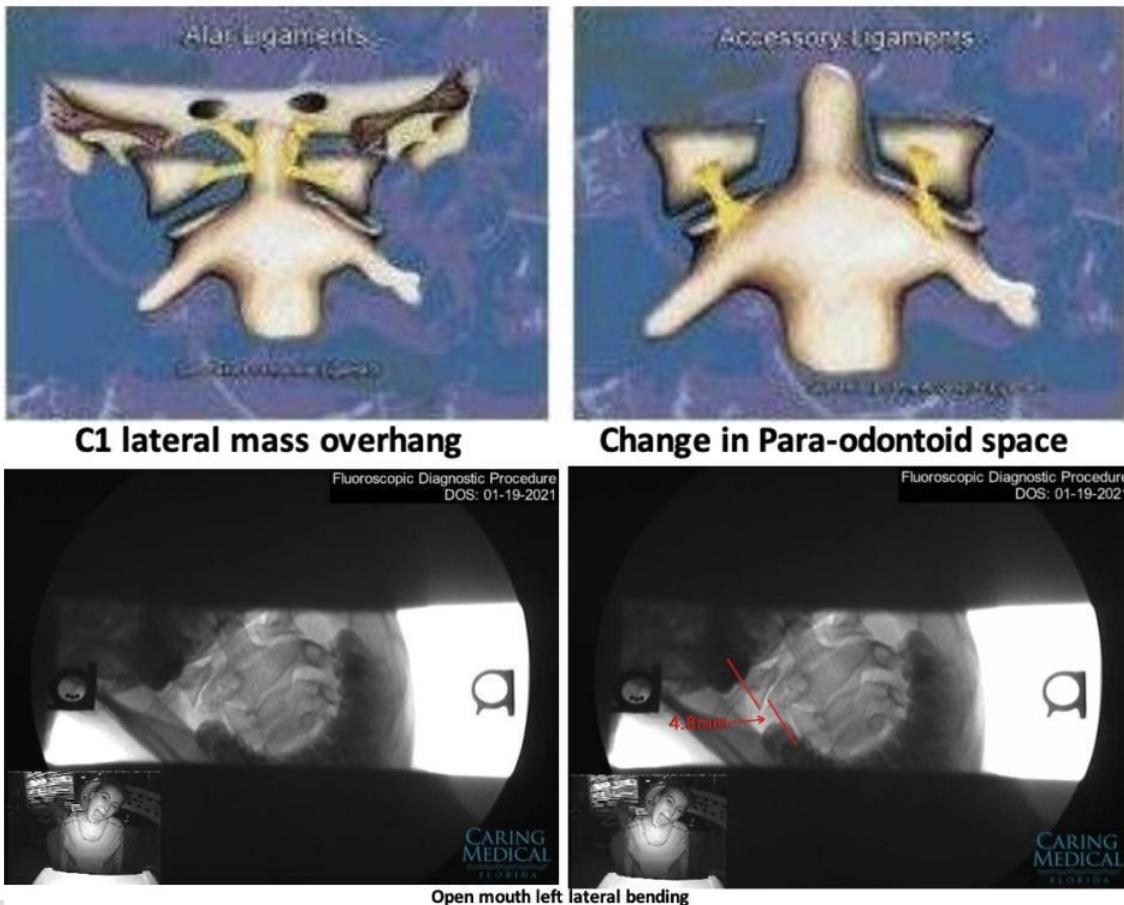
Digital Motion X-ray: significant abnormal lateral translation of C1 on C2 with 4.8mm overhang bilaterally on lateral flexion. This view examines the integrity of the alar and accessory ligaments either by the lateral overhang of C1 on C2 or by the changes in the para-odontoid spaces. Image courtesy of Agnes Stogicza, used with permission of the patient, RB.
